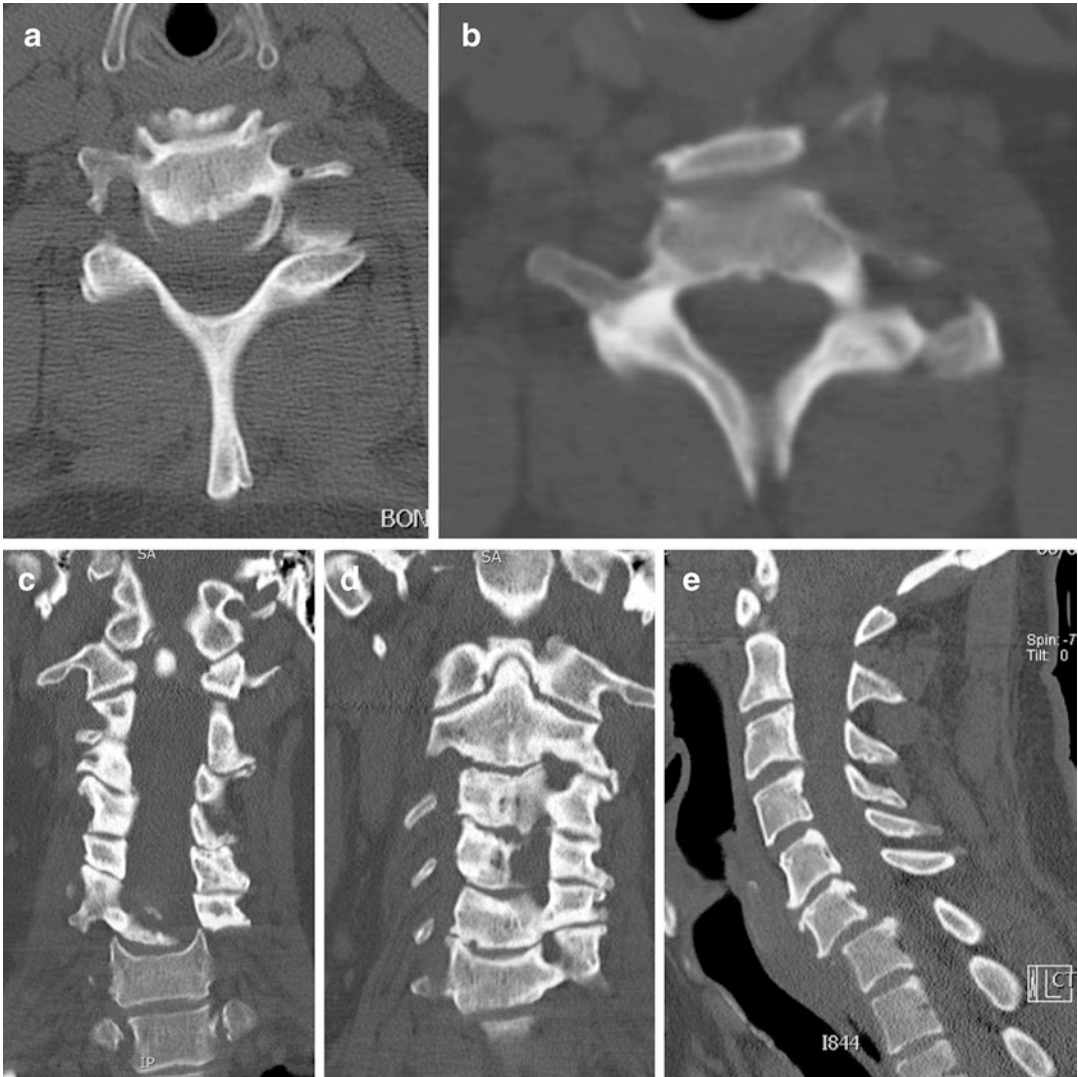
(a, b) Axial CT of the spine. (c, d) Coronal CT of the spine. (e) Sagittal CT of the spine
